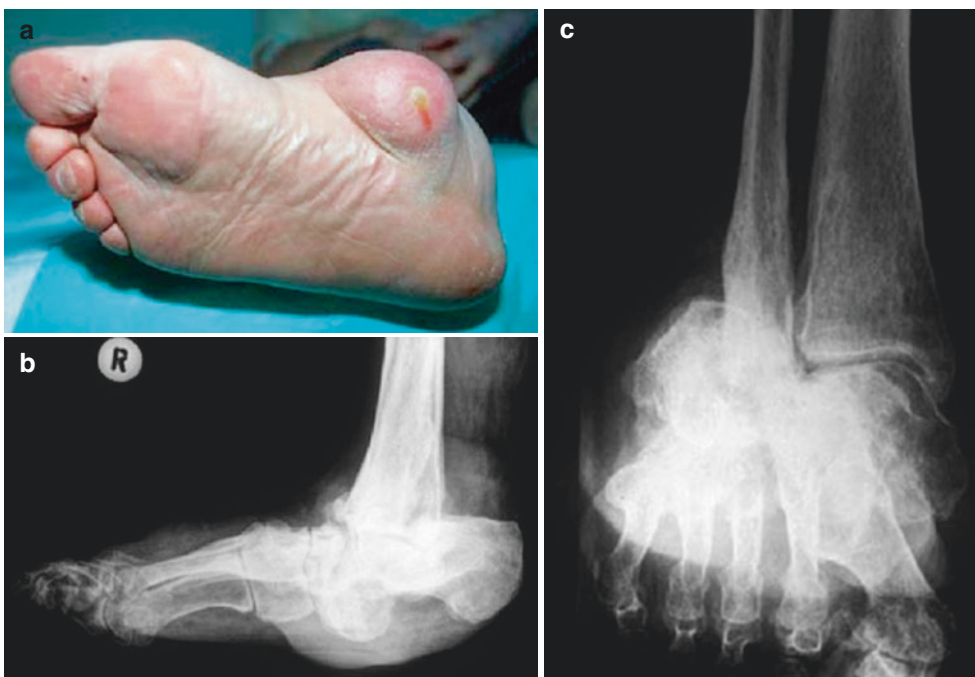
The use of imaging methods in CHOA diagnosis. (a) Clinical manifestation of rocker bottom foot deformity; (b, c) images in two projections; (d) 3D CT
